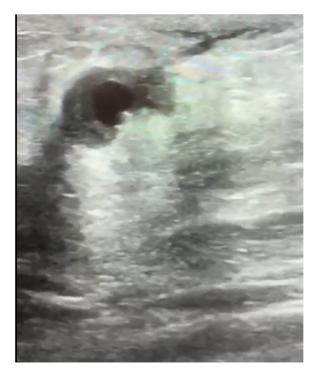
B-mode ultrasound image of the right breast mass showing a thick-walled lesion with a pulsatile anechoic center.
